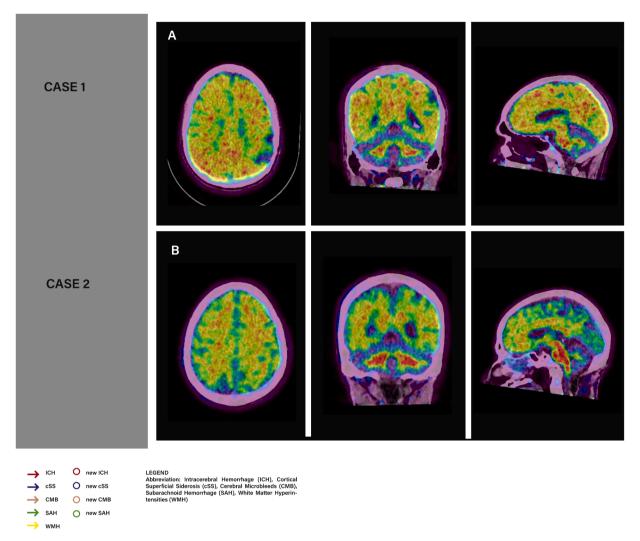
A. PET-CT shows B-amyloid deposits at the cortical level affecting both frontal, temporal, and parietal lobes in case 1. B. Cerebral PET-CT shows an absence of abnormal amyloid deposits in cortical regions in case 2.
